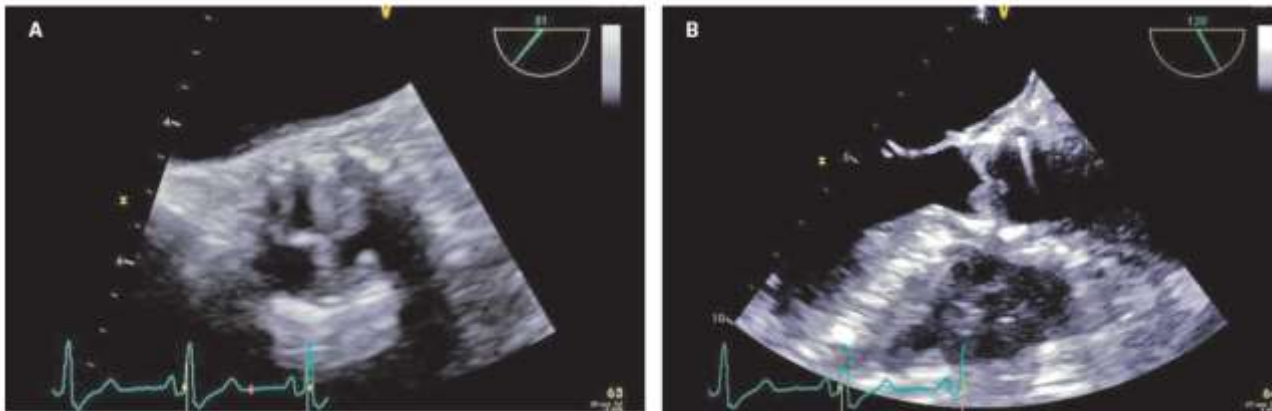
Transoesophageal echocardiography views of the prosthetic aortic valve before starting anticoagulation (short axis [A] and long axis [B]).
